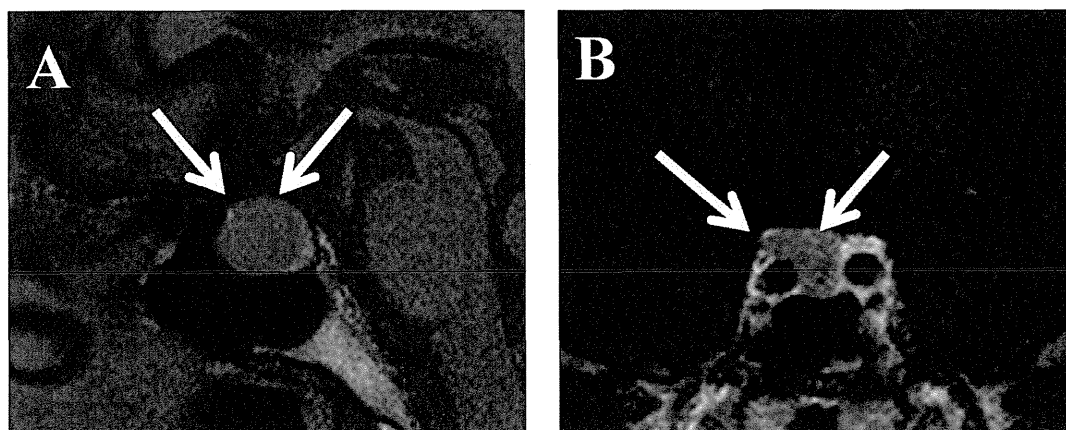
Brain magnetic resonance imaging (MRI) of the patient. Shown are the sagittal section of T1 weighted image (A) and the coronal section of enhancing image (B). A less enhancing lesion 2.5 cm in diameter suggesting a pituitary adenoma (indicating by arrows) was observed in the right wing on T1-weighted enhancing MRI (B).
